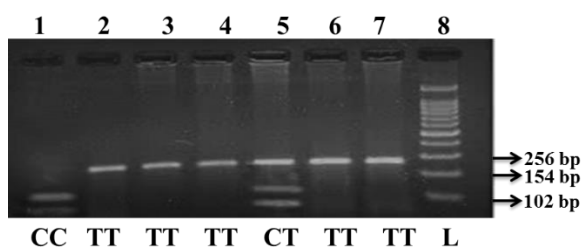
The RFLP analysis of the *ITGB3* gene was carried out by digesting the PCR-amplified product, producing distinct banding patterns corresponding to different genotypes. Lane 1 (CC) showed two fragments of 154 bp and 102 bp, indicating complete digestion of the PCR product. Lane 2 (TT) displayed a single undigested fragment of 256 bp, characteristic of the homozygous TT genotype. Lane 5 (CT) revealed three
